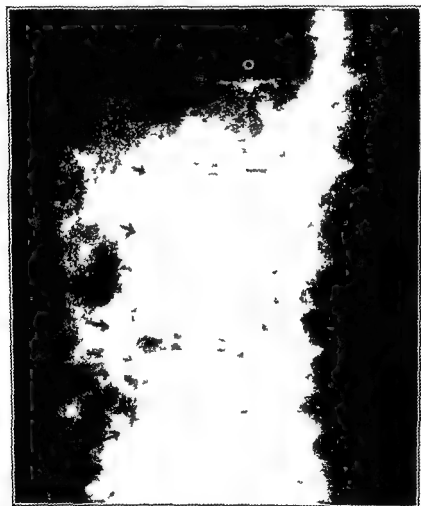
Lateral x-ray of hip joint in a case of ankylosing arthritis. Note the bony outgrowth indicated by the arrows.
